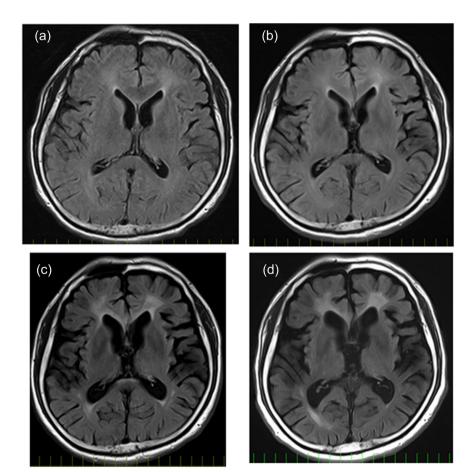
Brain magnetic resonance images in an axial section at the basal ganglia using a fluid attenuated inversion recovery sequence: (a) at the 13th hyperbaric oxygen (HBO) therapy session, (b) at the 72nd HBO therapy session, (c) 2 years after HBO therapy, and (d) 8 years after HBO therapy.
